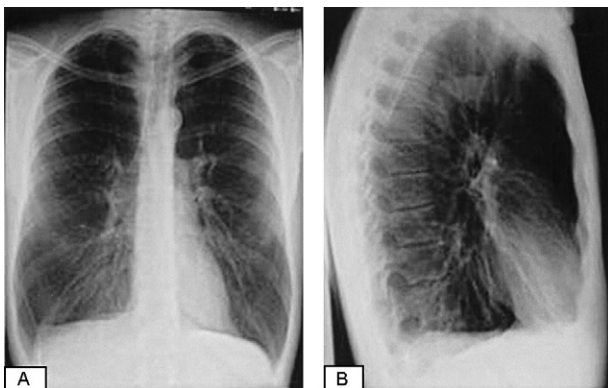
(A, B) Chest X-ray showing signs of emphysema (32-year-old male). Pleural drain is on the right side.
